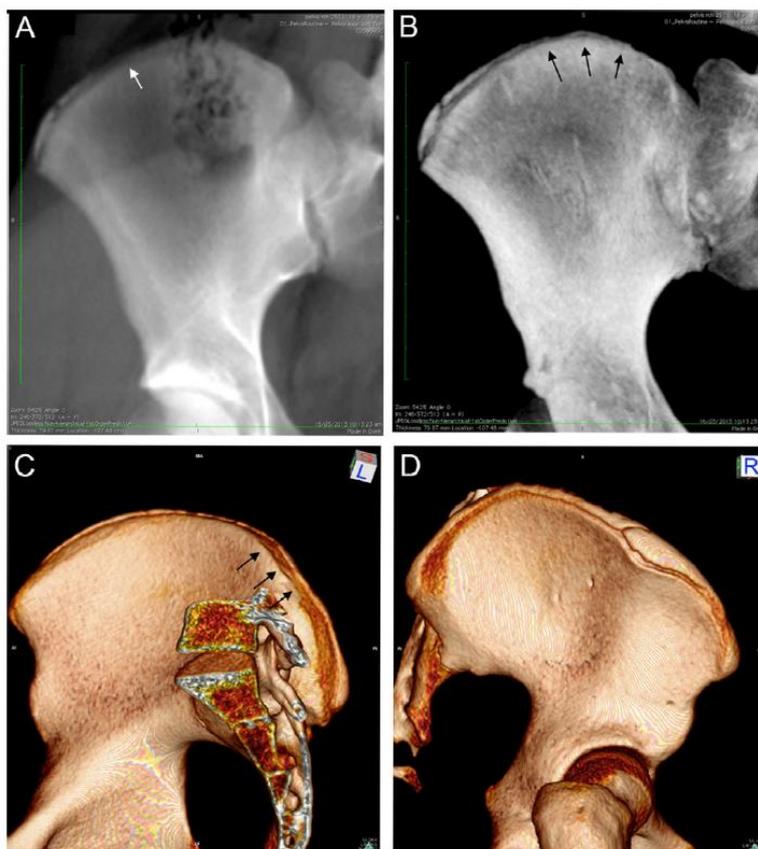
Example of Queensland Female (15 years), classified as Stage IV of the 3D-MSCT scoring system. Complete anteroposterior excursion of the iliac crest apophysis, compared to the maximum lengthwise dimension of the iliac bone from ASIS to PSIS, with partial fusion between the anterior/posterior apophyseal centers to form the iliac tubercle (D). Despite fusion commencing on the posterolateral aspect of the ilium, lateral to the PSIS, appositional growth of the posterior apophyseal center is incomplete, failing to extend to the medial surface of the iliac tuberosity (C). On a coronal pseudo-radiograph (MIP reformat; B), the apophysis is not visible (black arrows). Based on a mean reslice of 5mm increments (A), consistent with conventional radiography, the lateral transcendence of the apophysis presents as “pseudo-fused” (white arrow), while gas in the ascending colon partially obscures the field of view. Investigators not familiar with the three-dimensional ontogeny of the crest apophyseal fusion may confuse the coronal radiograph as stage II (greater than 50% of apophyseal ossification, with a large bone deficiency between the anterior and posterior centers, posterior to the most superior point of the iliac bone).
